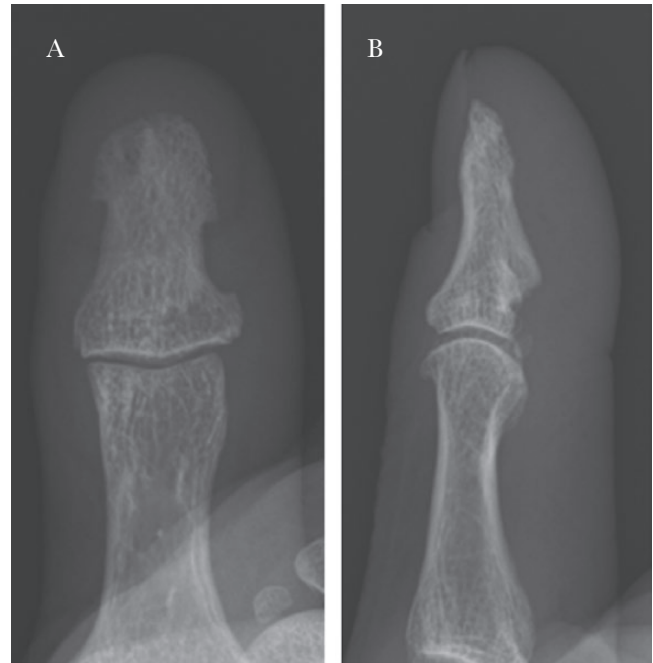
Plain x-ray images of the phalanx of the right thumb 2 years after the surgery. A, Frontal view. B, Lateral view.
